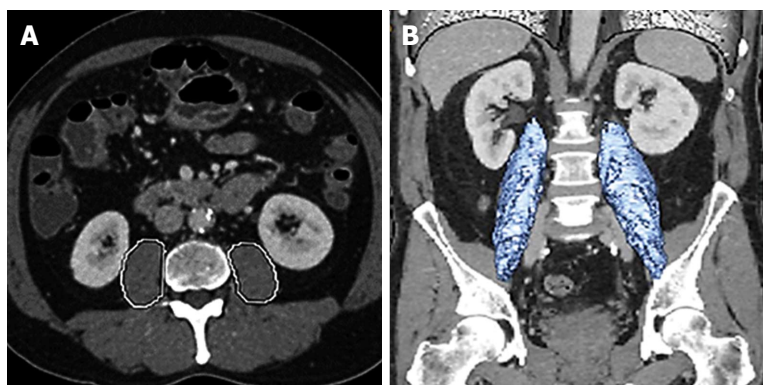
Define sarcopenia rather than a single axial image. A: Total psoas area is measured by circling both psoas muscles at the level of the patients computed tomography where both iliac crests are visible; B: Total psoas volume is measured at the full length of the psoas muscles and normalized for the patients body surface area. Used with permission Amini *et al*^[47], 2015.
